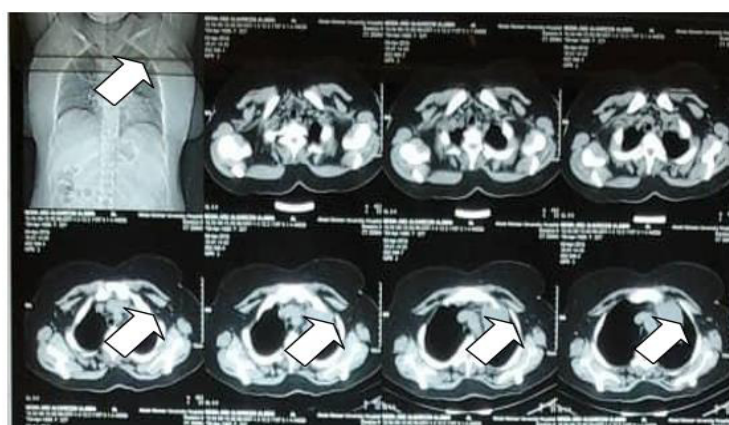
CT chest without contrast mediastinal window
